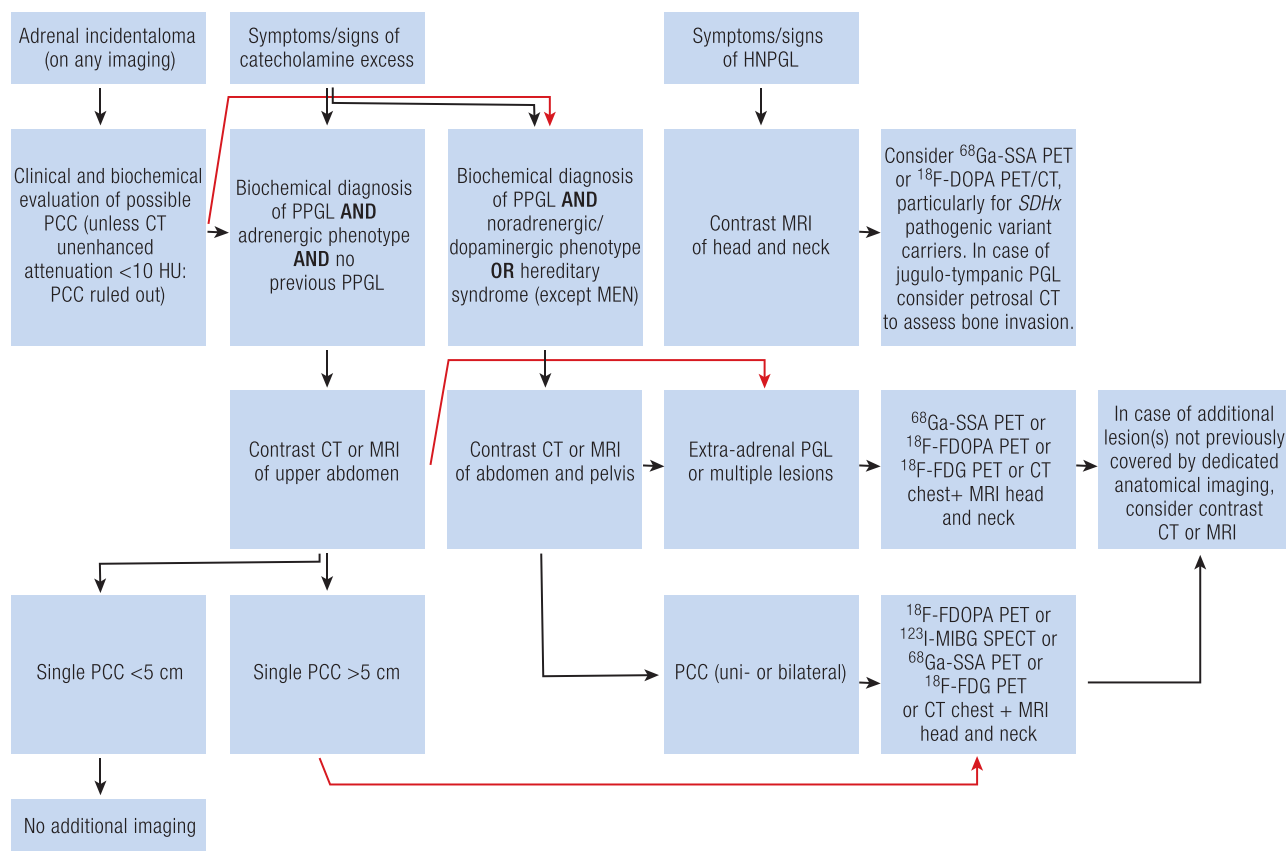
Imaging algorithm for initial diagnosis. Definitions: Plasma metanephrines (normetanephrine or metanephrine), or methoxytyramine 2 of more times the upper reference limit (61). Adrenergic tumors are defined by an elevated plasma metanephrine of >0.31 nmol/L and by an increase in plasma metanephrine of $>5\%$ of the total increments in plasma normetanephrine and metanephrine beyond their upper reference limits (63). Abbreviations: 3MT, 3-methoxytyramine; CT, computed tomography; FDG, fluorodeoxyglucose; FDOPA, fluorodihydroxyphenylalanine; HNPGL, head and neck paraganglioma; MEN2, multiple endocrine neoplasia type 2; MIBG, metaiodobenzylguanidine; MN, metanephrine; MRI, magnetic resonance imaging; NMN, normetanephrine; PCC, pheochromocytoma; PET, positron emission tomography; PPGL, pheochromocytoma/paraganglioma; SPECT, single photon emission computed tomography; SSA, somatostatin analogue.
